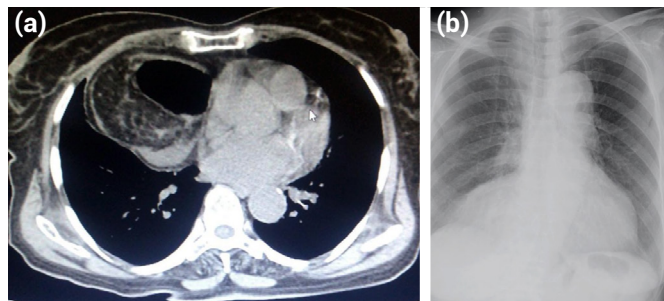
(a) A right sided Morgagni hernia on abdominal CT. (b) Colonic hydro-aero levels on chest X-Ray.
